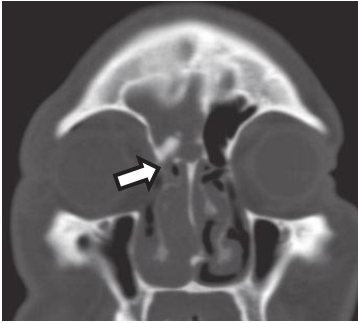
Coronal CT of the frontal sinus showing injury to the nasofrontal recess (*arrow*). The nasofrontal recess is an hourglass-shaped structure and is not a true duct. The caudal portion is composed of the frontal sinus infundibulum; the cephalad portion is composed of the ethmoid infundibulum. Injury to the nasofrontal recess is best assessed with coronal cuts. Notice that the nasofrontal recess is patent on the contralateral uninjured side.
